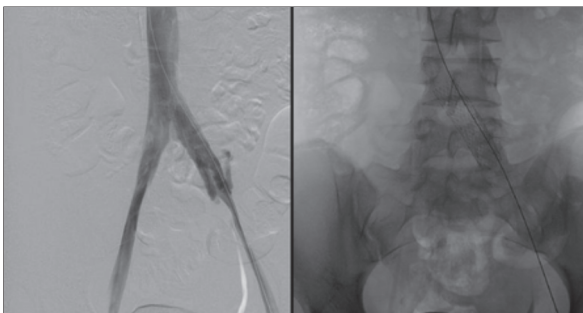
May-Thurner syndrome treated by placement of a dedicated venous stent in the common iliac vein (left - last control venography; right - control plain X-ray).
